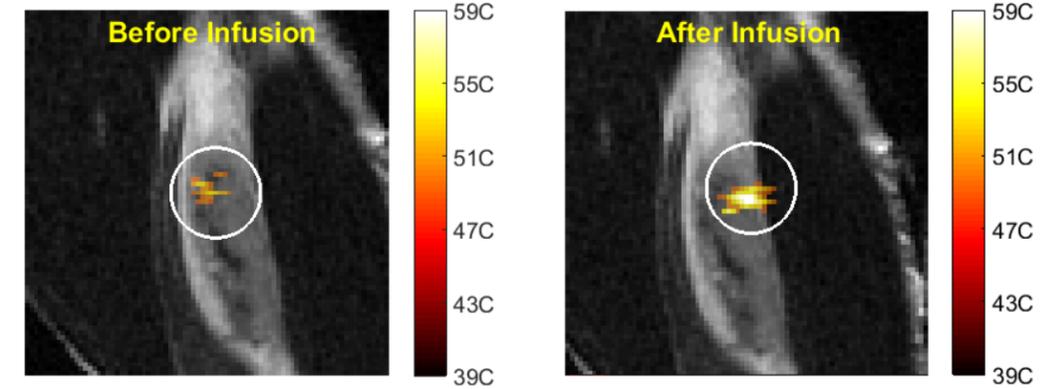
Temperature maps in rabbit tumors after 30 seconds of sonication with high-intensity focused ultrasound (HIFU) using magnetic resonance (MR) thermometry. Sonications were performed before or after infusion of phase-change nanodroplets. The presence of nanodroplets resulted in an increased peak temperature and heating area. From Kopechek et al. (2014).
